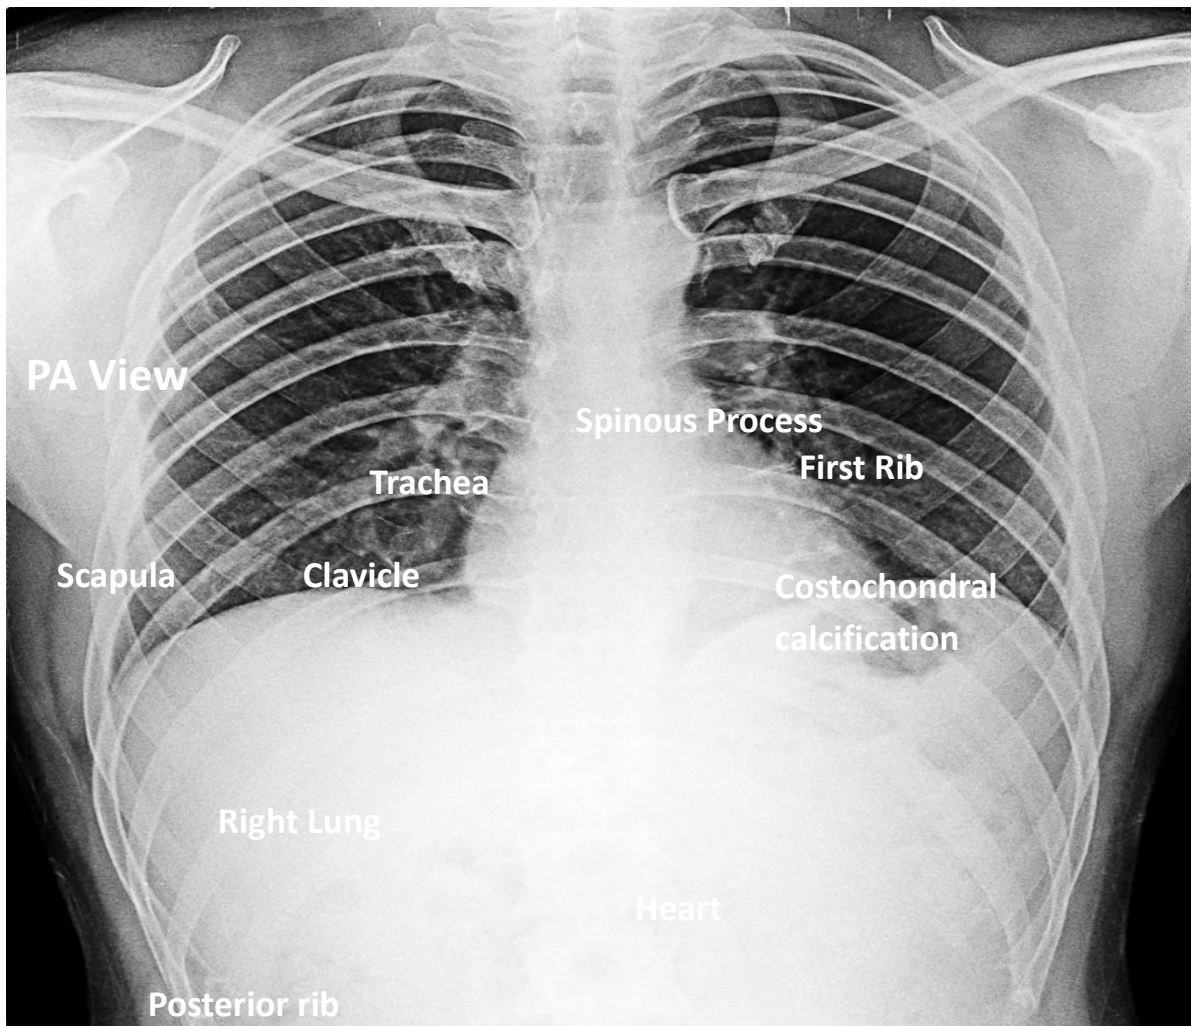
A normal chest radiograph
